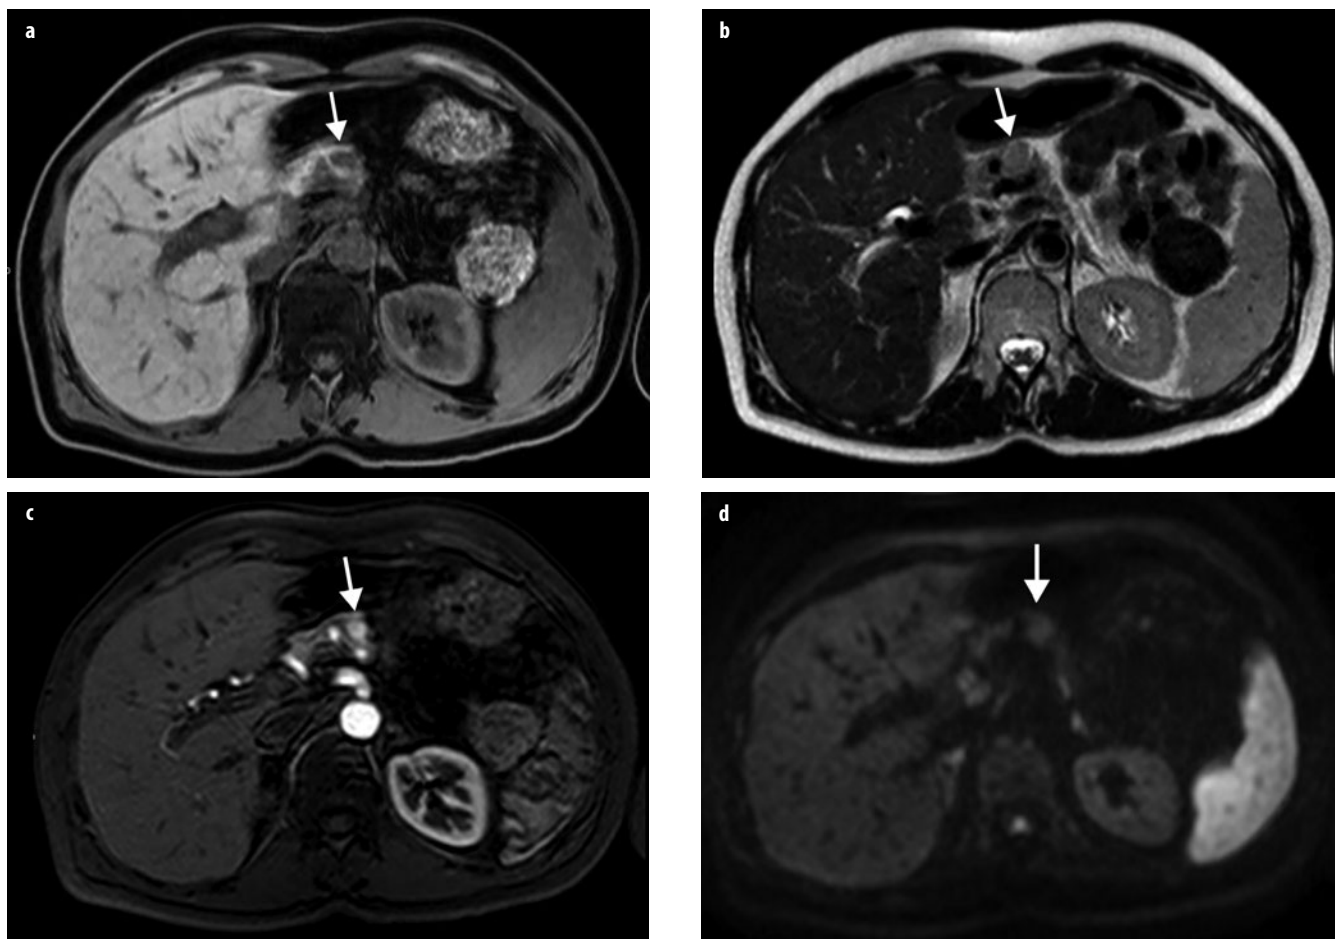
a-d. Small neuroendocrine neoplasm. a Axial T1-weighted gradient echo (GRE) image (TR/TE 180/4.66 ms) with fat saturation shows a neuroendocrine neoplasm that appears hypointense compared with adjacent pancreatic parenchyma (*arrow*). b Axial T2-weighted turbo spin-echo (TSE) image (TR/TE 4,500/102) shows a small neuroendocrine neoplasm that appears hyperintense compared with adjacent parenchyma (*arrow*). c On the axial fat-saturated volumetric T1-weighted GRE image (TR/TE 4.86/1.87 ms) during the pancreatic phase of the dynamic study following gadolinium-chelate administration, the neuroendocrine neoplasm appears hyperintense compared with adjacent pancreatic parenchyma (*arrow*). d On axial diffusion-weighted image (DWI) ($b=1000$) the neuroendocrine neoplasm shows restricted diffusion (*arrow*)
